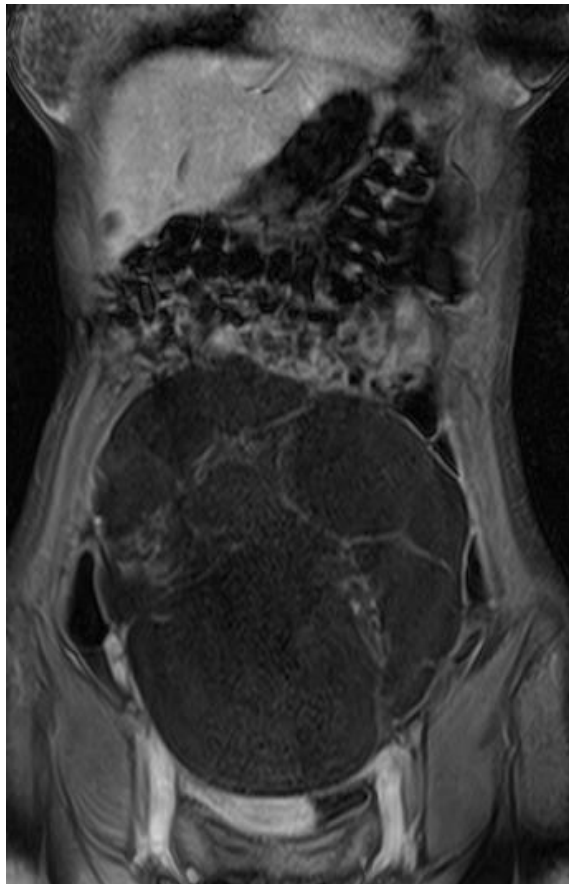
T2-weighted image in sagittal plane. Voluminous abdominal-pelvic mass. Sagittal T2-weighted image with predominantly liquid signal, multiseptate, including solid areas.
